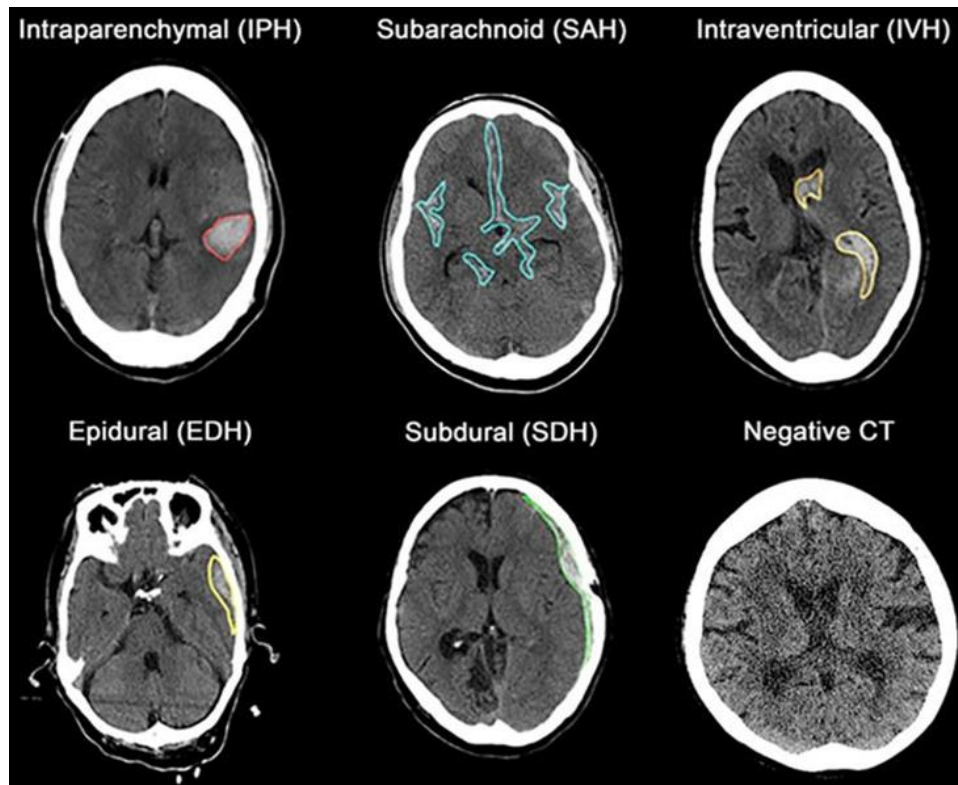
Non-contrast Computed Tomography scans for ICH sub-types. Note. Reprinted from (Kim, 2021)
